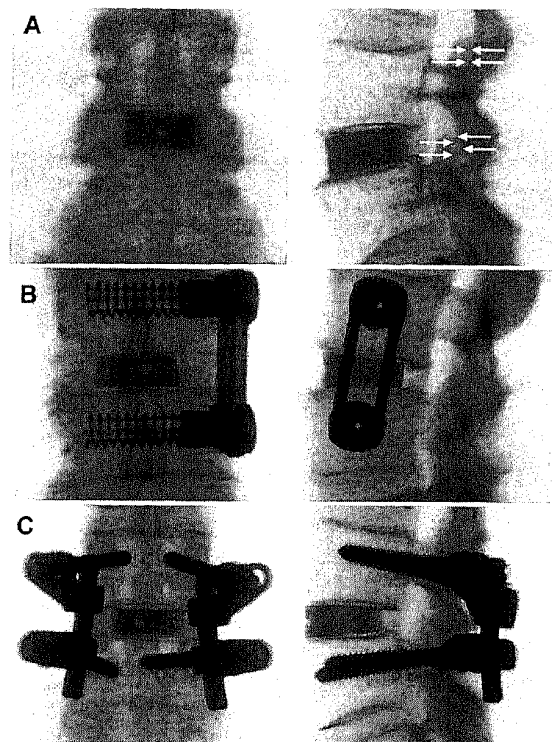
Anteroposterior and lateral radiographs demonstrating features of ALIF after application of an FRA and two different supplementary fixation systems. A: Stand-alone ALIF resulted in increased intervertebral space and distracted facet joints compared with upper facet joints (arrows). B: Additional lateral fixation with MACS HMA plate/screw instrumentation. C: Additional posterior transpedicular screw fixation with a TiMX system.
